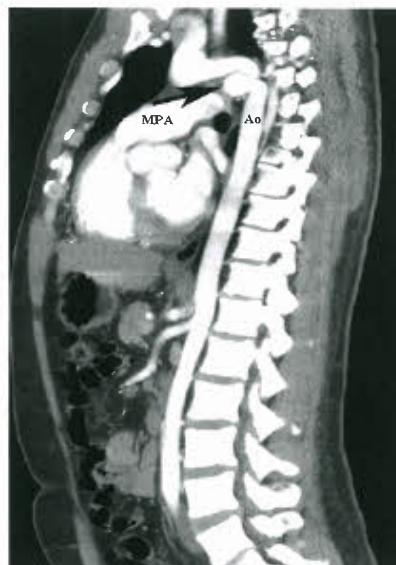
CT scan of a young adult showing a large ductal aneurysm.
